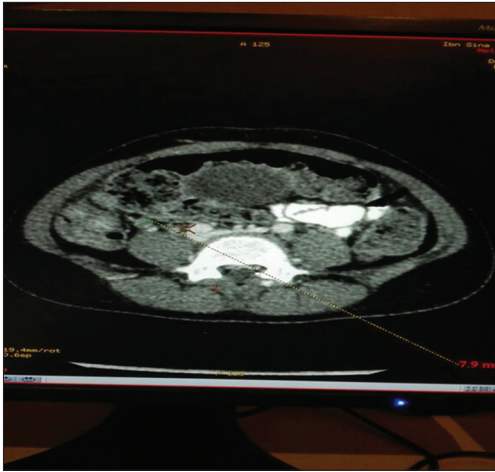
Computed tomography scan - suggestive of acute appendicitis measuring 7.9 mm diameter
